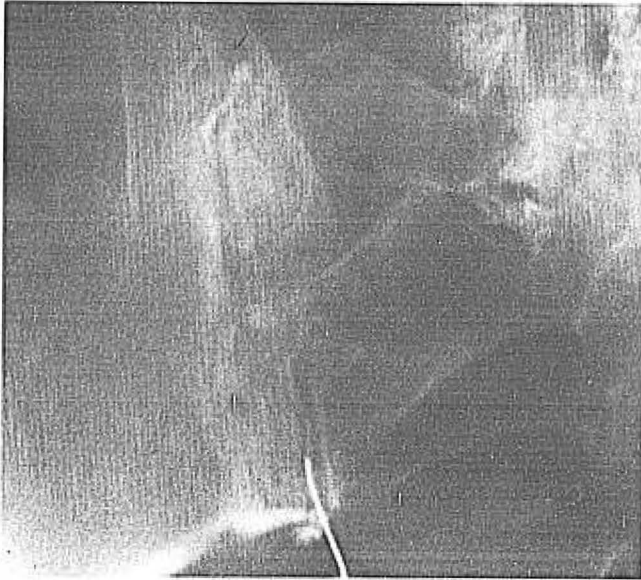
Prone view of an arthrogram of the left sacroiliac joint demonstrating correct needle position and spread of contrast within the joint. Radiographic contrast fills a small inferior subcapsular recess.
